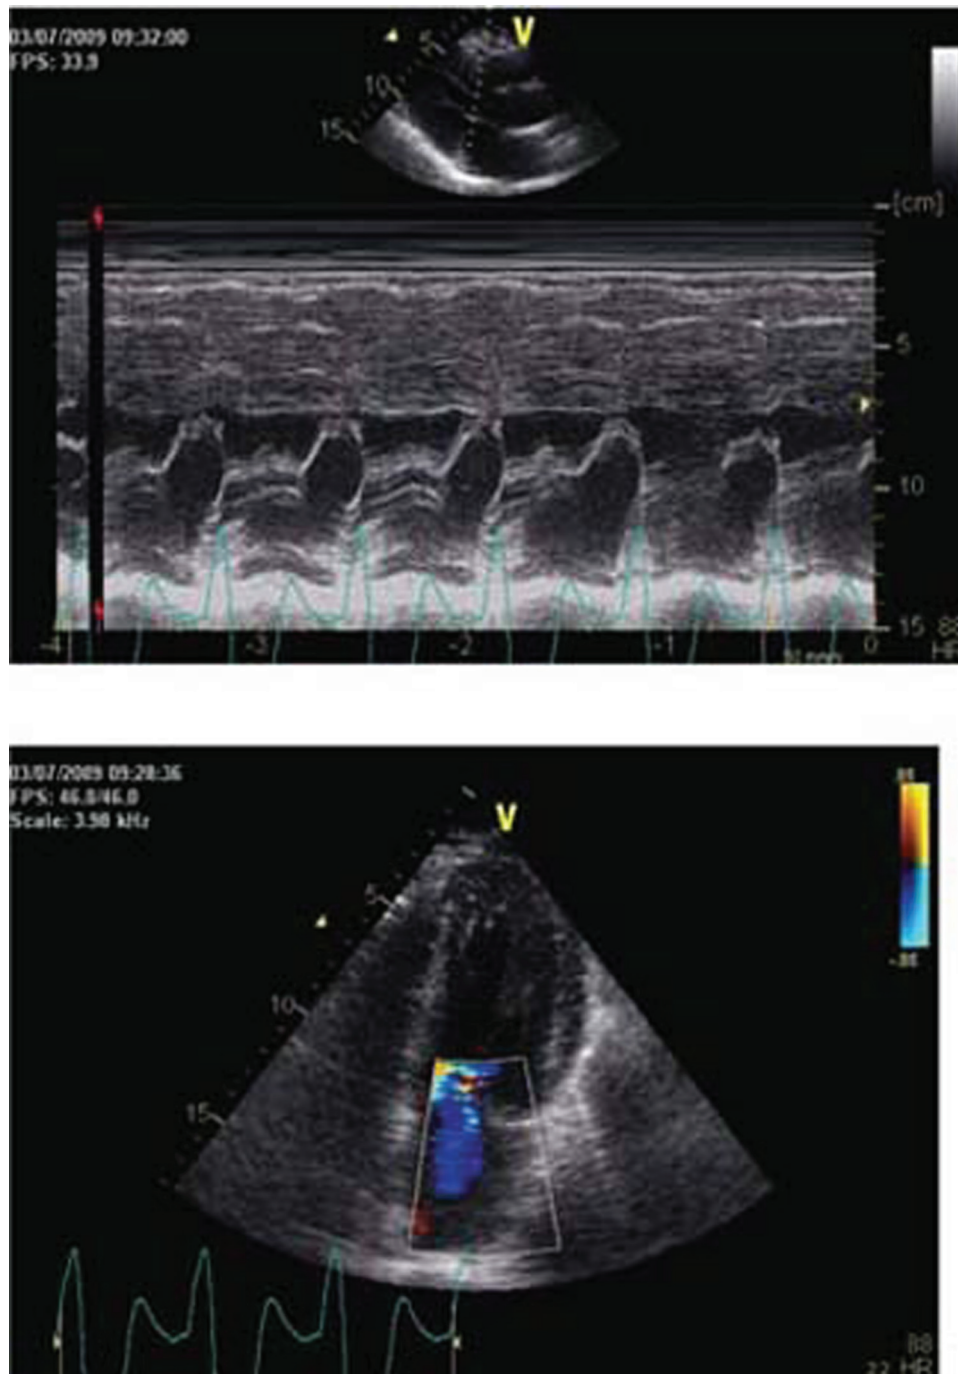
(A,B) After dual-chamber pacing with a short atrioventricular delay, M-mode Doppler shows complete resolution of systolic anterior motion of the mitral valve and colour Doppler shows only mild mitral regurgitation.
